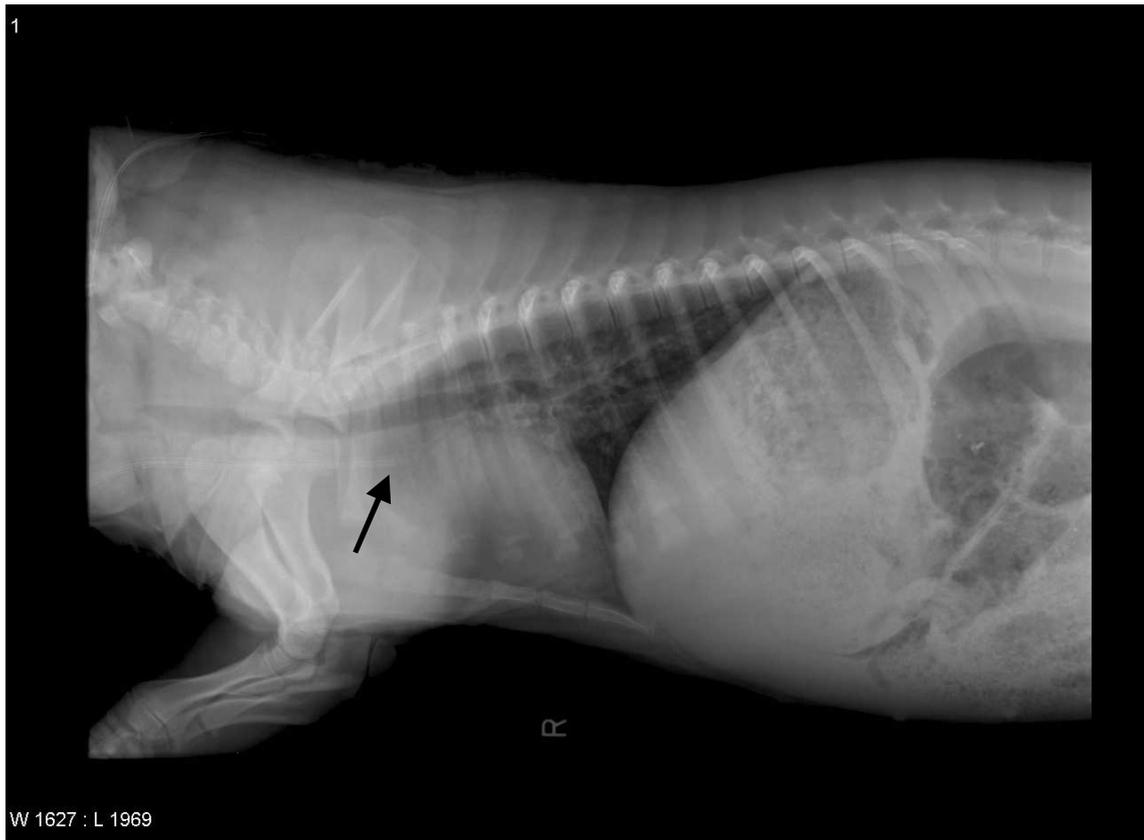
Latero-lateral thoracic radiograph for determination of catheter placement (arrow marks the end of the catheter near the heart base)
